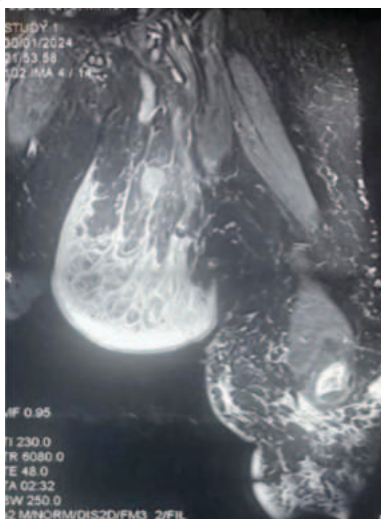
MRI Image Of Swelling
